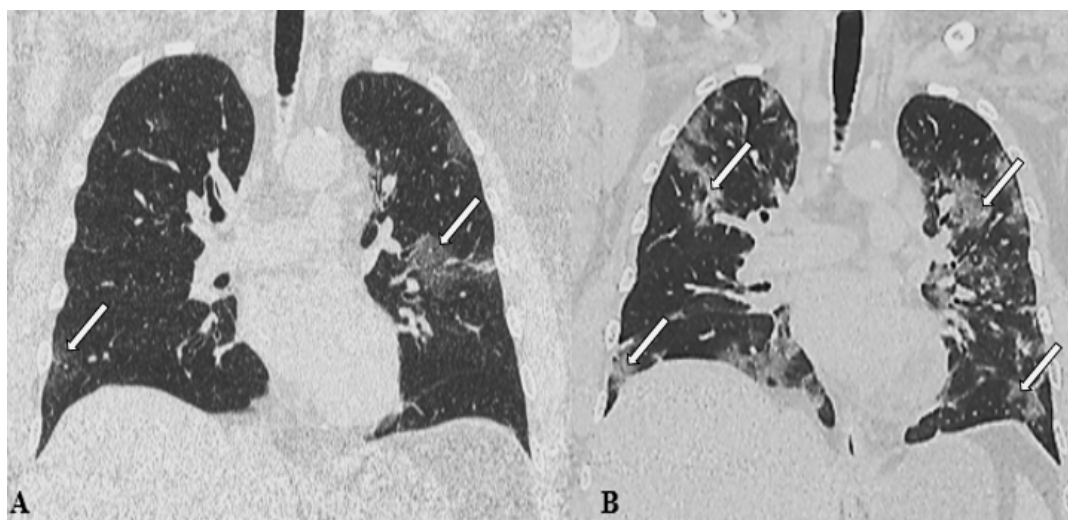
Chest CT on the first emergency care, revealing typical findings of Covid-19 pneumonia (A). Examination after 10 days reveals worsening of the findings (B).
